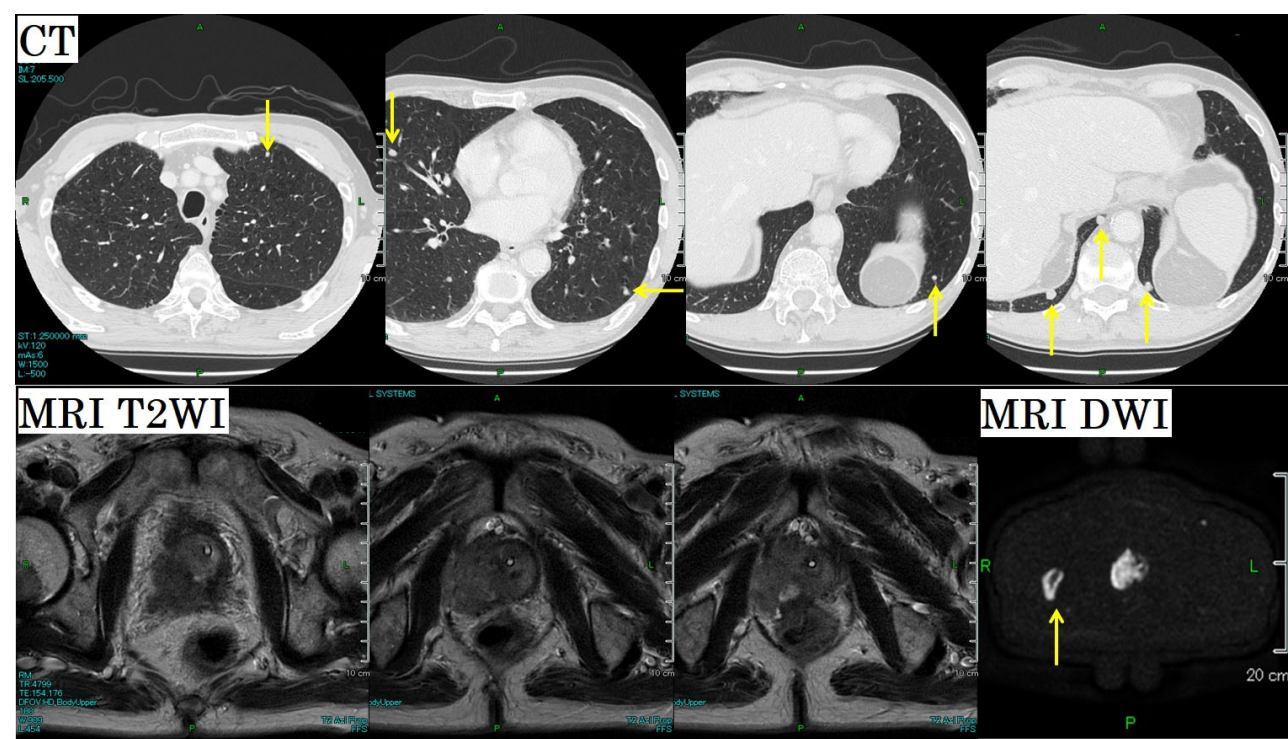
Computed tomography and magnetic resonance imaging showed multiple lung metastases and advanced bone metastases.
